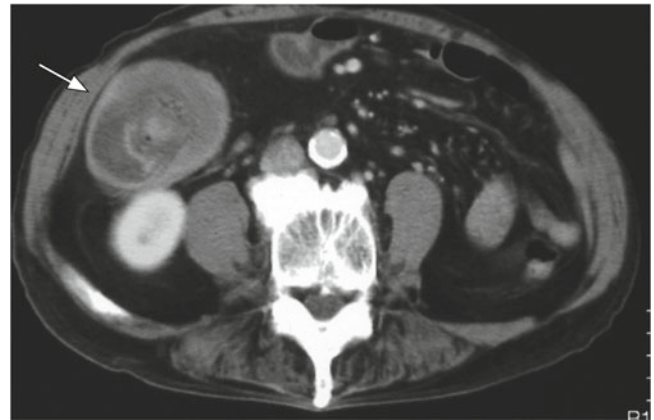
Contrast-enhanced CT showed a stratified enhancing effect in the interior of the lesion, and the lesion in the terminal ileum had slid into an adjacent portion, causing intestinal intussusception at the cecum
